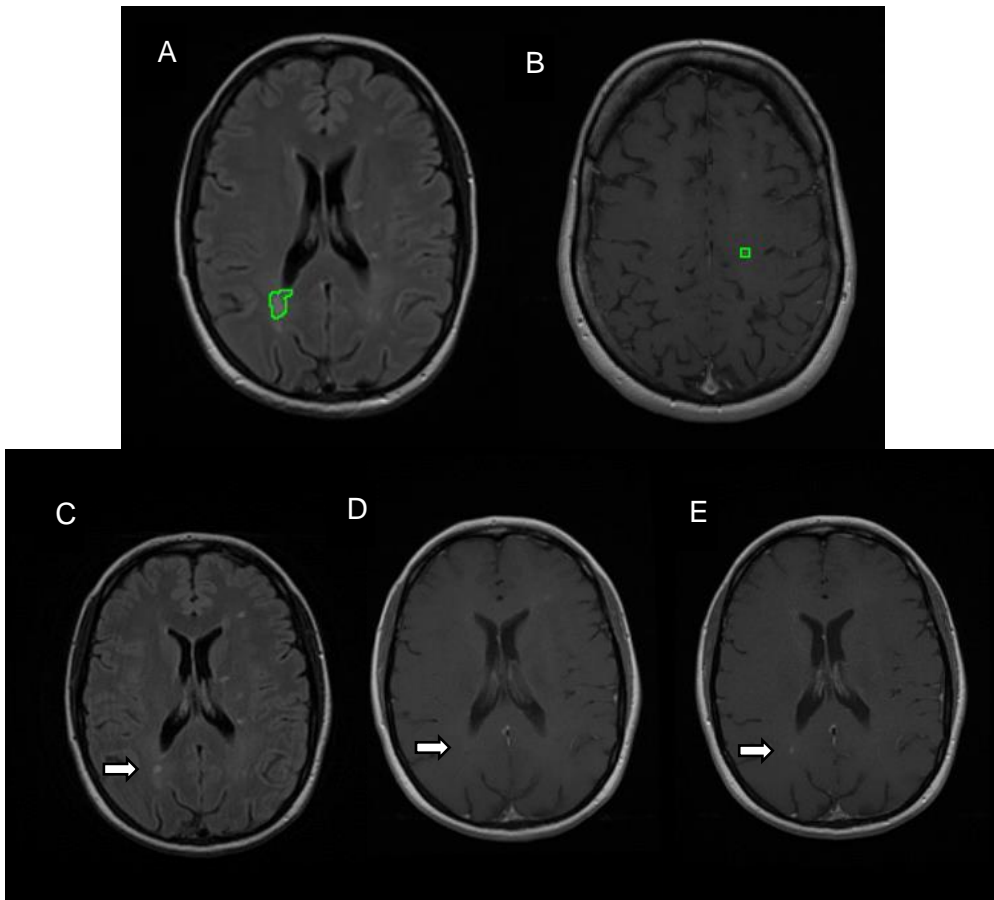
(A) Demonstration of lesion (marked with ROI) on FLAIR; (B) Demonstration of contrast-enhancing lesion (marked with ROI) on T1-weighted Gd+ MRI (C) patient xx V9 FLAIR MRI (marked with arrow) (D) patient xx V9 T1 (marked with arrow). (E) patient xx V10 T1 (marked with arrow).
